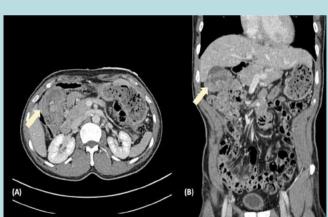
CT showing intussusception at the hepatic flexure containing low attenuation mass (arrow) in the (A) axial and (B) coronal view
